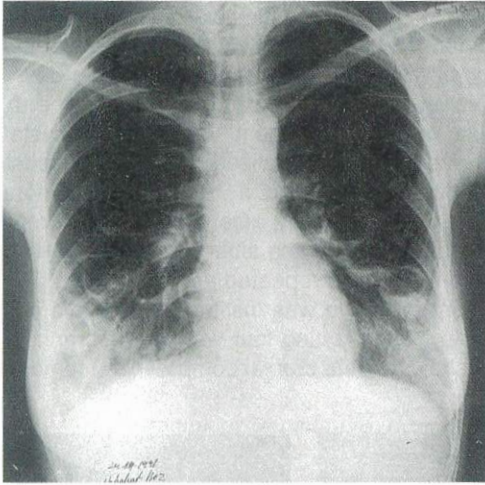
X-ray showing cyst condition after one course of therapy.
